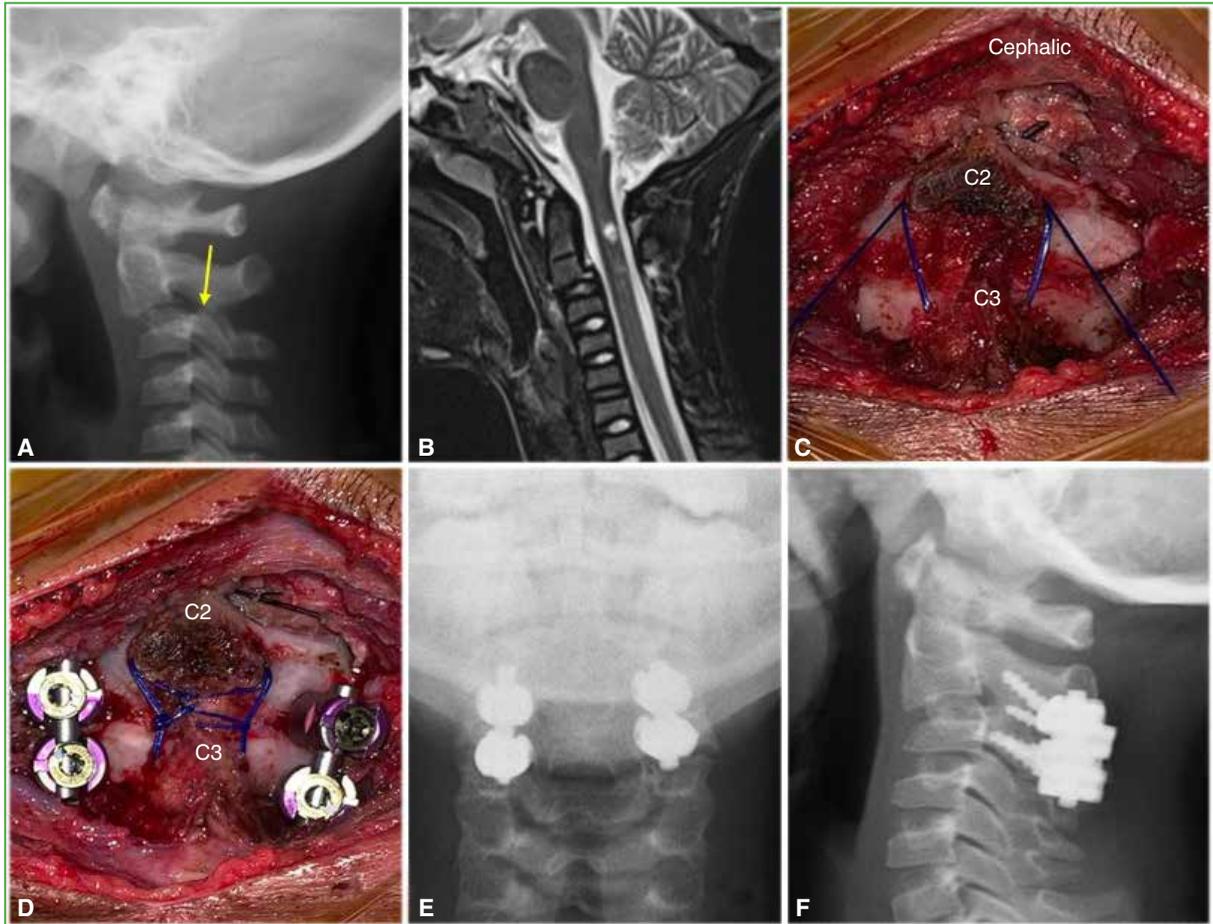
8-year-old boy, victim of a frontal motor vehicle collision, presenting with pneumothorax, traumatic brain injury, mechanical ventilation for 2 weeks, and central spinal cord syndrome. Referred with a 2-month history. A. Lateral radiograph of the cervical spine showing pathological C2-C3 subluxation with minimal facet contact (yellow arrow). B. Magnetic resonance imaging showing perivertebral and intramedullary hyperintense signal on T2-weighted sequences. C. Intraoperative image showing suture technique as in Figure 2, using blue suture material. D. Intraoperative image showing facet osteosynthesis. E and F. Radiographic follow-up images obtained 2 years after surgery.
